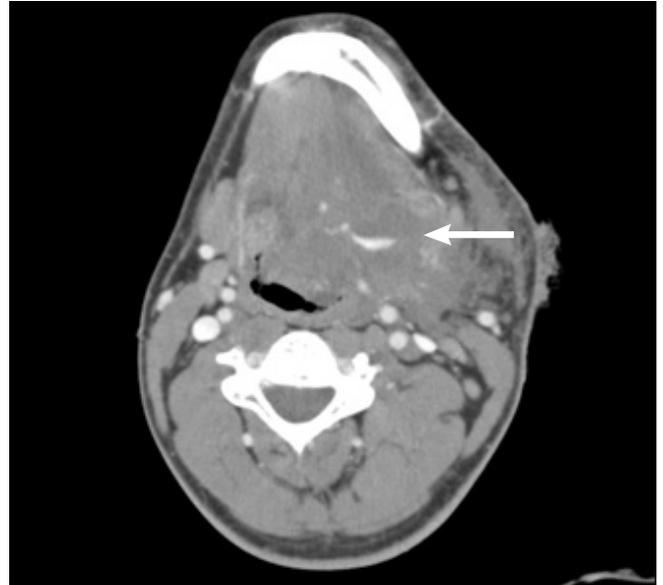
The first computed tomography image of the neck revealed an active bleeding focus (arrow) in the left mandibular space.
